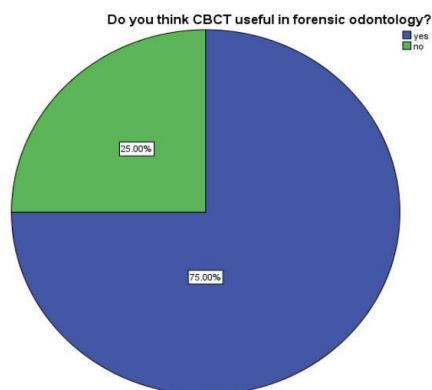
Pie chart shows the awareness about the participants whether CBCT is useful in forensic odontology . 75 % said yes and 25% said no. Blue colour indicates yes and green colour indicates no.
